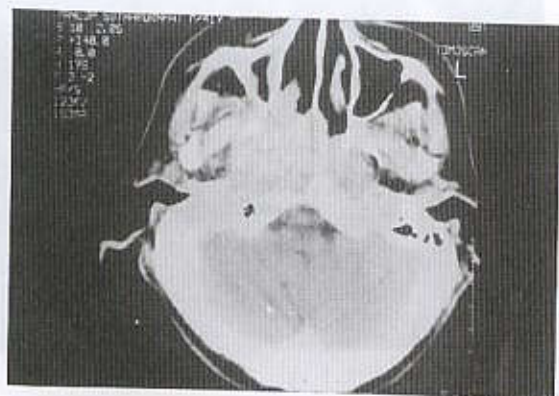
Axial/coronal CT of clinical stage T3 shows tumor extension to the cranial cavity via destruction of the base of the skull. Therefore, the CT stage is stage T4.
